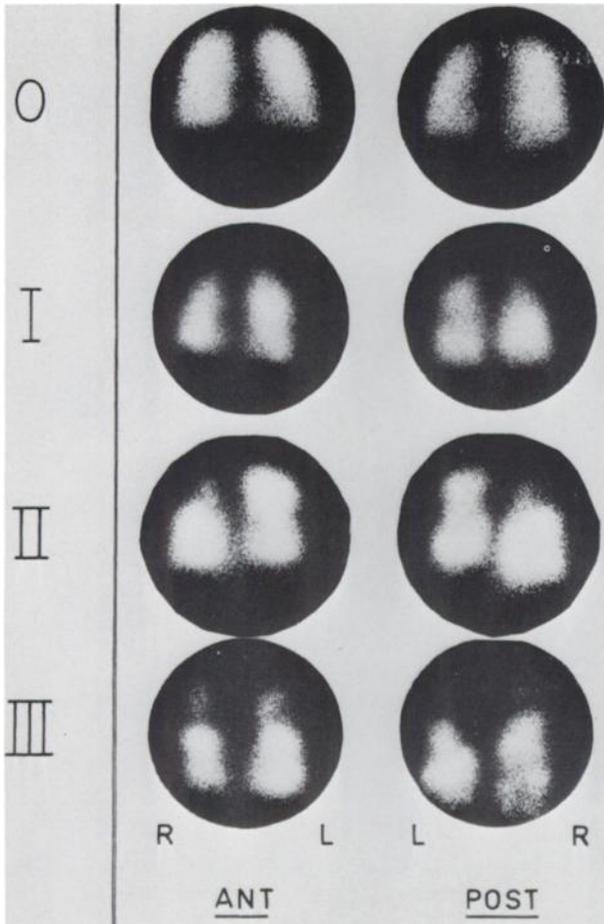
Classification of pulmonary lesions on basis of scintigraphy.
